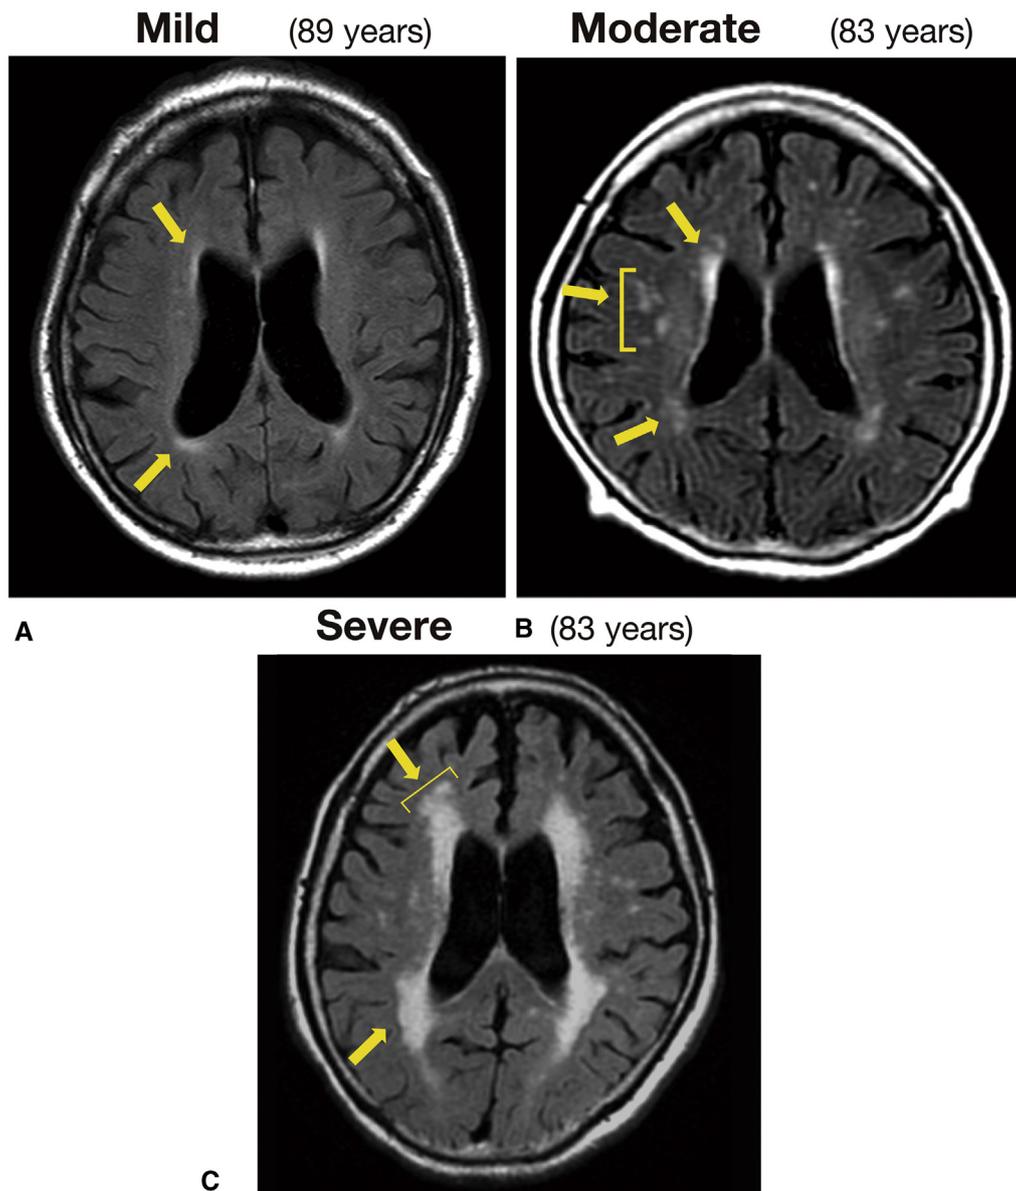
Magnetic resonance images of mild (A), moderate (B), and severe (C) white matter changes on the Fazekas visual scale. The *arrows* indicate the white matter changes.
